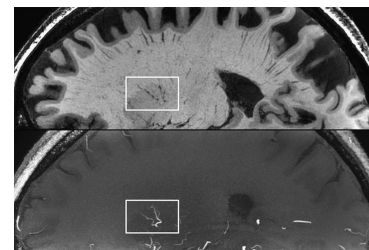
Seven tesla offers unparalleled spatial resolution in imaging of the brain, opening new opportunities both for the study of normal anatomy and disease. In the example presented, 7 T offers detailed visualization of the perivascular spaces in the basal ganglia in an elderly woman, which is of potential utility in the study of these fluid-filled cavities in aging and small vessel disease. Note also the prominent generalized dilatation of the perivascular spaces. T1-weighted and 3-dimensional (3D) time of flight magnetic resonance angiography images are presented. Reprinted with permission from Bouvy et al.³⁷
